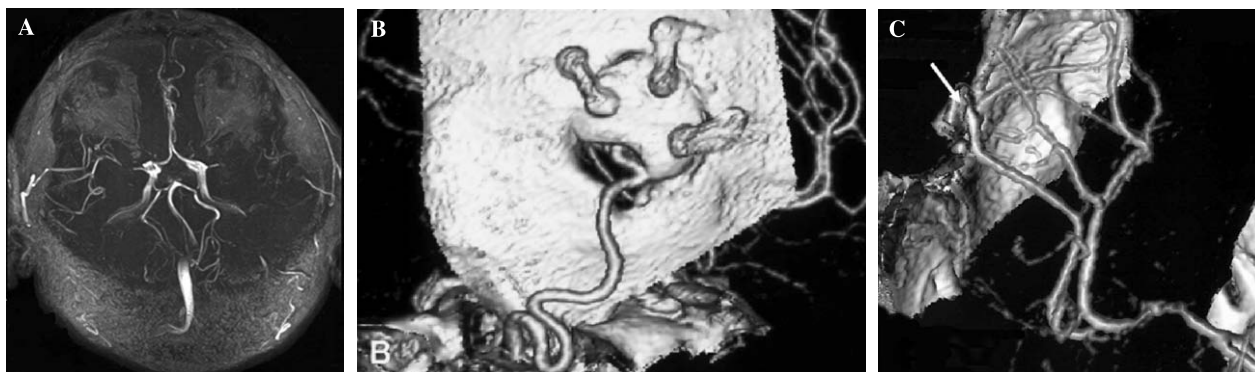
(A) Postoperative MRA shows the patency of the EC-IC bypass. (B) Postoperative 3D CTA from the view of outside the skull shows the patency of the EC-IC bypass. (C) Postoperative 3D CTA from the view of inside the skull shows the patency of the EC-IC bypass. Arrow indicates the site of anastomosis
